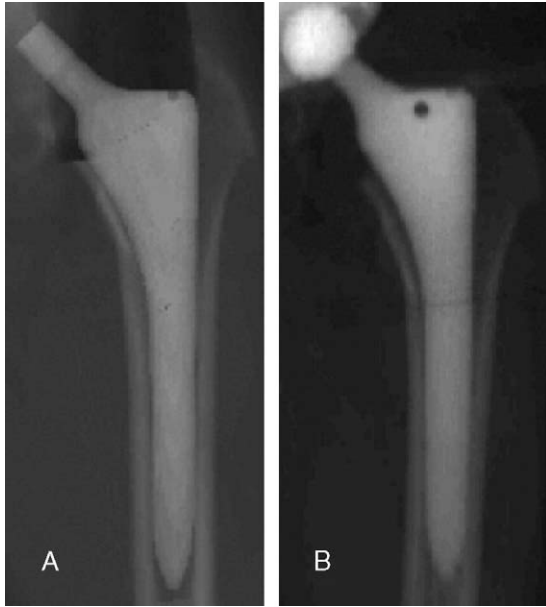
A 53-year-old man with degenerative arthritis underwent THA using a handheld rasp. A, Anteroposterior synthetic radiograph of the proximal femur from preoperative planning. B, Anteroposterior synthetic radiograph reconstructed from CT data obtained 1 month postoperatively.
